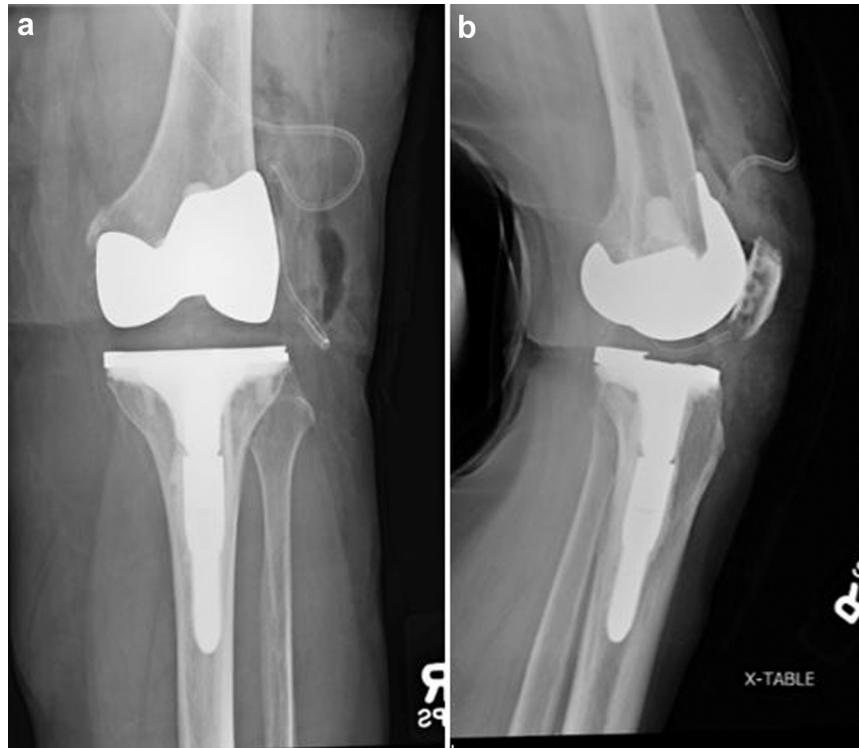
Primary TKA radiographs. Anteroposterior (a) and lateral (b) immediate postoperative radiographs of TKA performed at outside facility.
